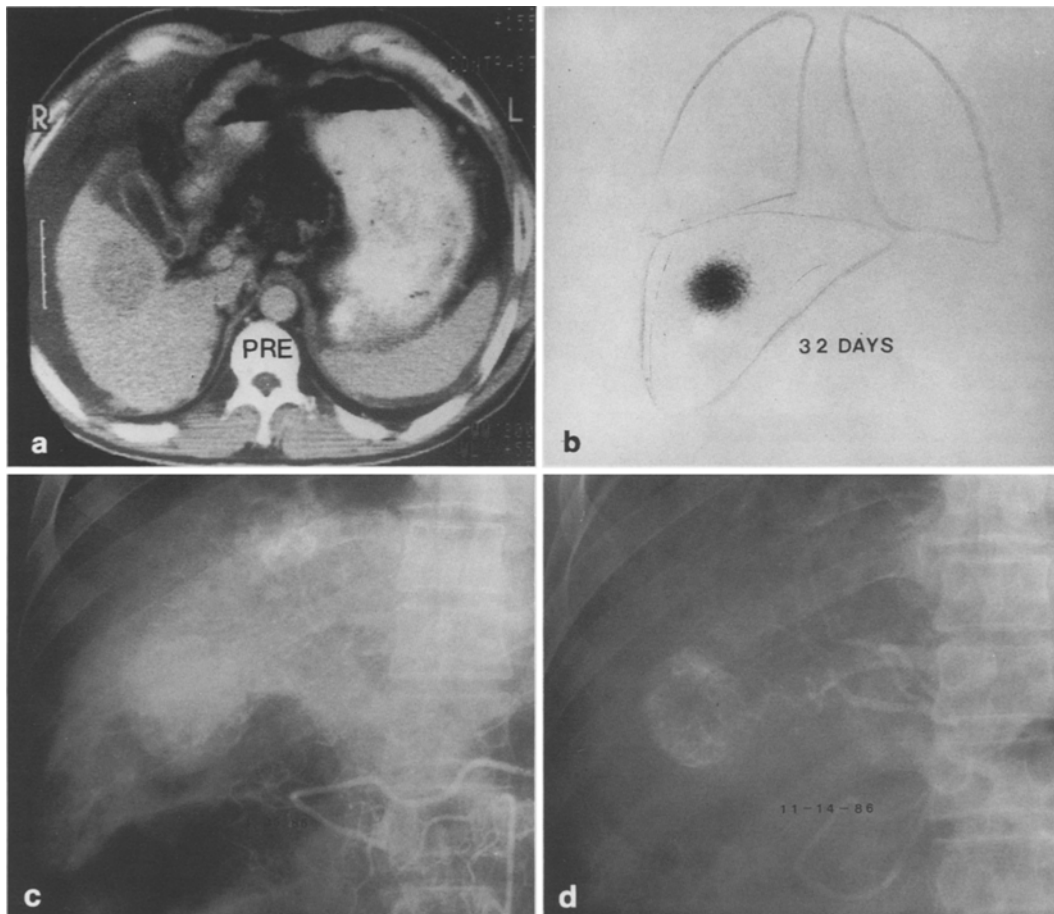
a Computed tomography scan reveals well-defined low-density mass in the right lower lobe and ascites. b [^{131}I]lipiodol radioactivity is still seen in the tumor mass even after a 32-day follow-up period. c Angiography shows hypervascular mass consistent with massive type of hepatocellular carcinoma. d Nine-month follow-up angiography depicts contracted mass with central radiolucency suggestive of tumor necrosis
